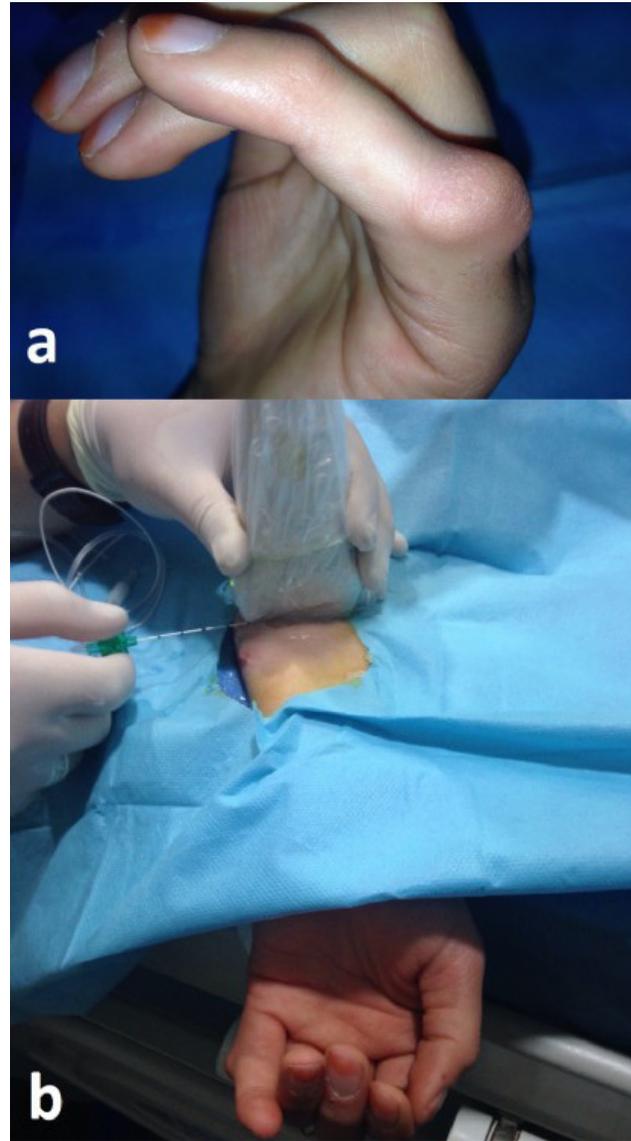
Left hand 5th finger exocytosis (a) Ultrasound probe and needle position(b)
